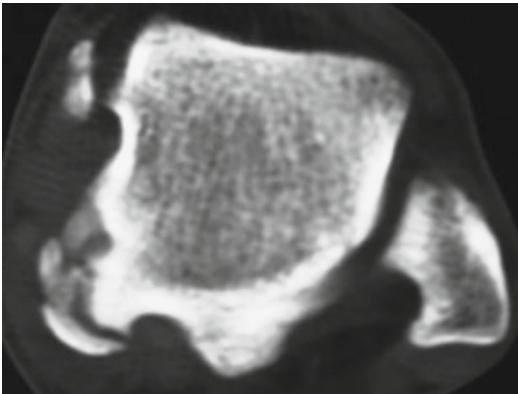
One of our cases with posteromedial ankle tenderness. Posterior impingement test was negative. CT scan represented prominent posteromedial talar process
